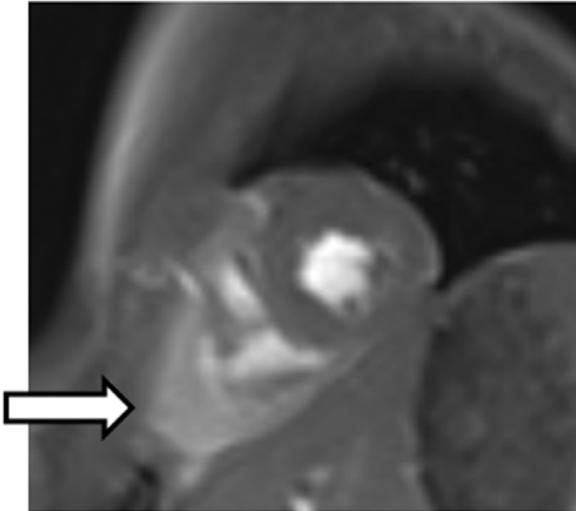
T2A hyperintense areas of pathologic contrast enhancement in the anterolateral and inferolateral walls of left ventricle in the evaluation by Cardiac MRI.
